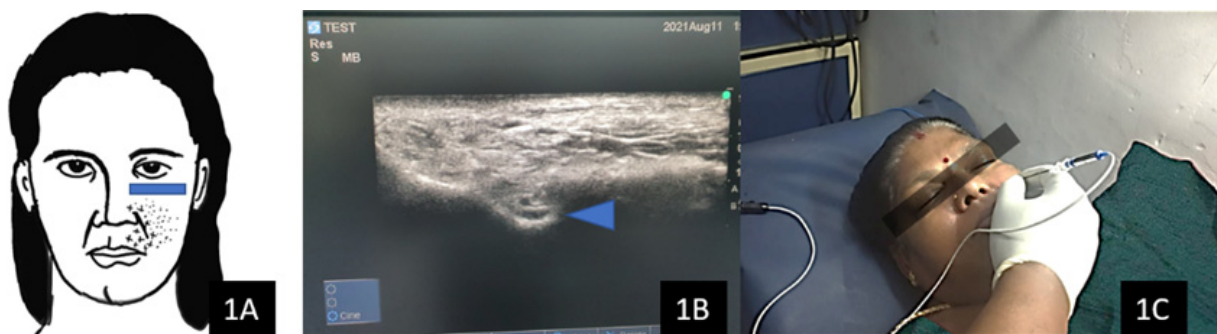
(A) Area of initial pain (crosses) and radiation (dots); the box represents ultrasound probe position. (B) Ultrasound image showing the infraorbital foramen and artery (arrowhead). (C) Pulsed radiofrequency needle in place.
